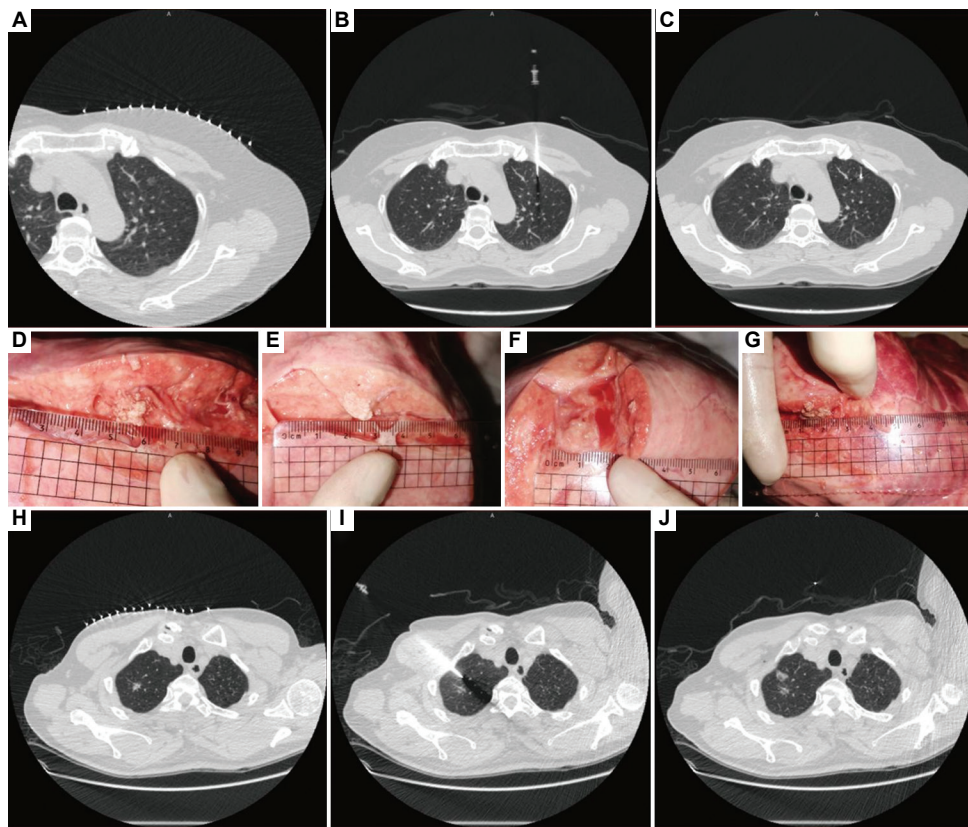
CT-guided localization needle placement and medical glue injection for pulmonary nodule management. (A) Patient 1; pre-localization CT scans show an 8 mm nodule, (B) localization needle adjacent to the nodule without penetration, and (C) needle anchored near the nodule with no complications like pneumothorax or hemorrhage. (D-G) Formation of hard masses after medical glue injection; 9 mm (D, 0.3 mL), 12 mm (E, 0.5 mL), 14 mm (F, 0.7 mL), and 15 mm (G, 0.9 mL). (H) Patient 2; pre-localization CT scans show a 15 mm nodule and (I) needle adjacent to the nodule without penetration, (J) while post-injection CT scan shows the position of the nodule and glue, with no complications like cough or pneumothorax. Abbreviation: CT: Computed tomography.
